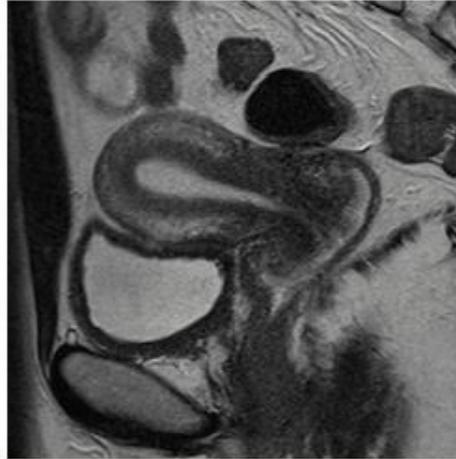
Representative case of a 34-year-old woman with a normal uterus. On T2-weighted images, the uterus shows three distinct layers: a high signal endometrium, a low signal junctional zone, and an intermediate-signal outer myometrium.⁴⁵
